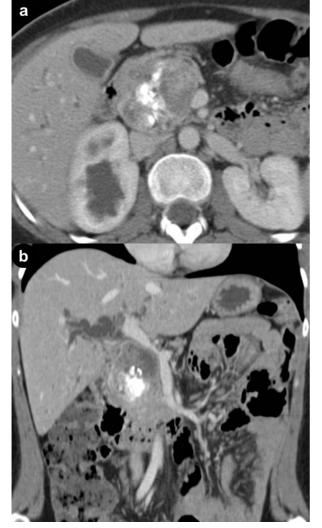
a. On dynamic CT scanning (portal phase), the pancreatic mass is solid, well demarcated and inhomogenously enhanced; dense calcifications are evident; as a collateral finding the right kidney presents pyelectasis from pyelo-ureteral junction syndrome. b. Coronal reformation displays an intratumoral cyst-like area superiorly; compression on the portal vein and dilatation of the intrahepatic biliary tree are also visible. Intraoperatively, the tumor infiltrates the portal vein.
